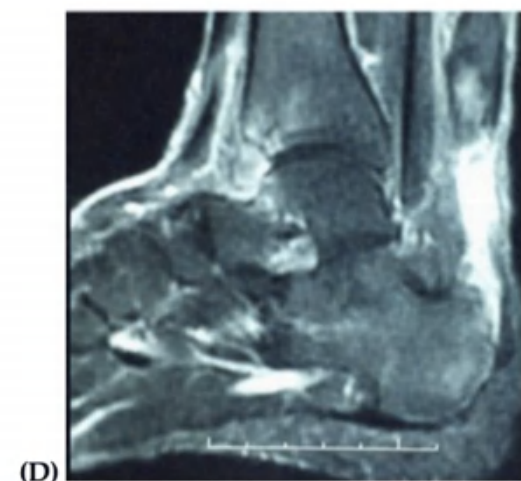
MRI image of a case presented by Sadek., et al. Showed a chronic and complete right Achilles tendon rupture with a 2,4 cm gap. This case is included in Kuwada's classification type II (complete tear < 3 cm defect) and Myerson's classification type II (complete tear 2-5 cm defect).¹⁹
